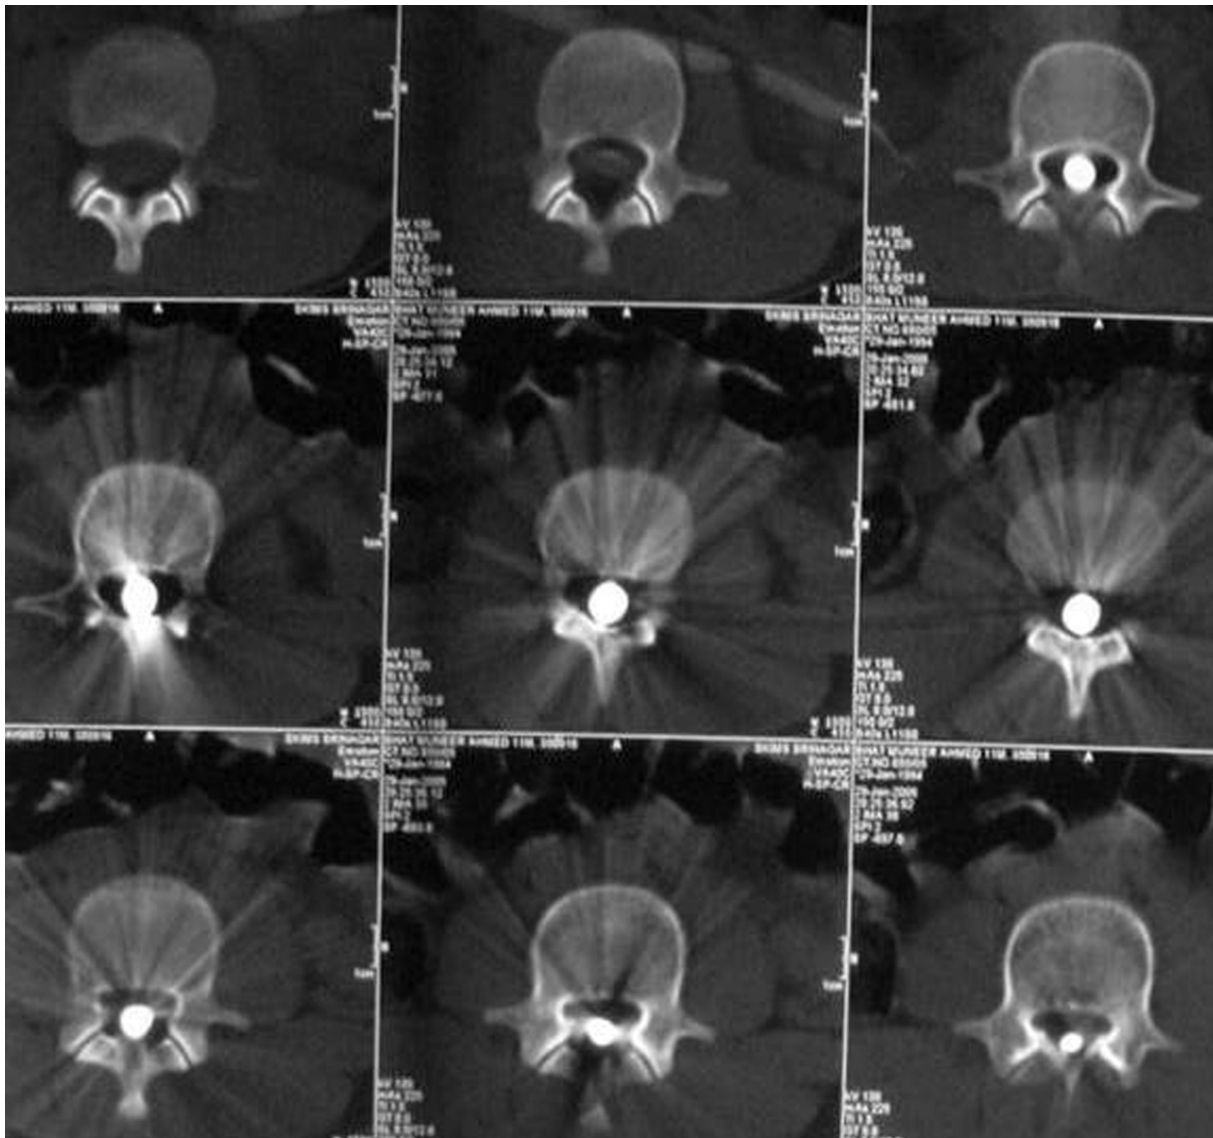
Plain axial CT-scan reveals, Second-Flight of a Bullet, process of migration of a metallic-bullet with its long axis sagittally inside lower dorsal spinal canal (See Fig. 10).
